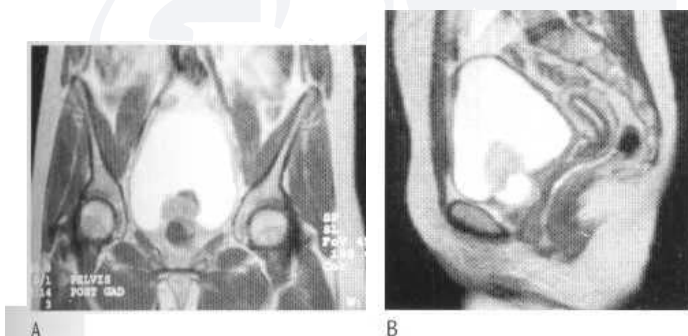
MRI scan on a young adult female with a bladder base rhabdomyosarcoma. Coronal postcontrast T₁-weighted (A) and sagittal T₂-weighted images (B) show a large heterogeneous mass of tumour invading the anterior wall of the vagina.
